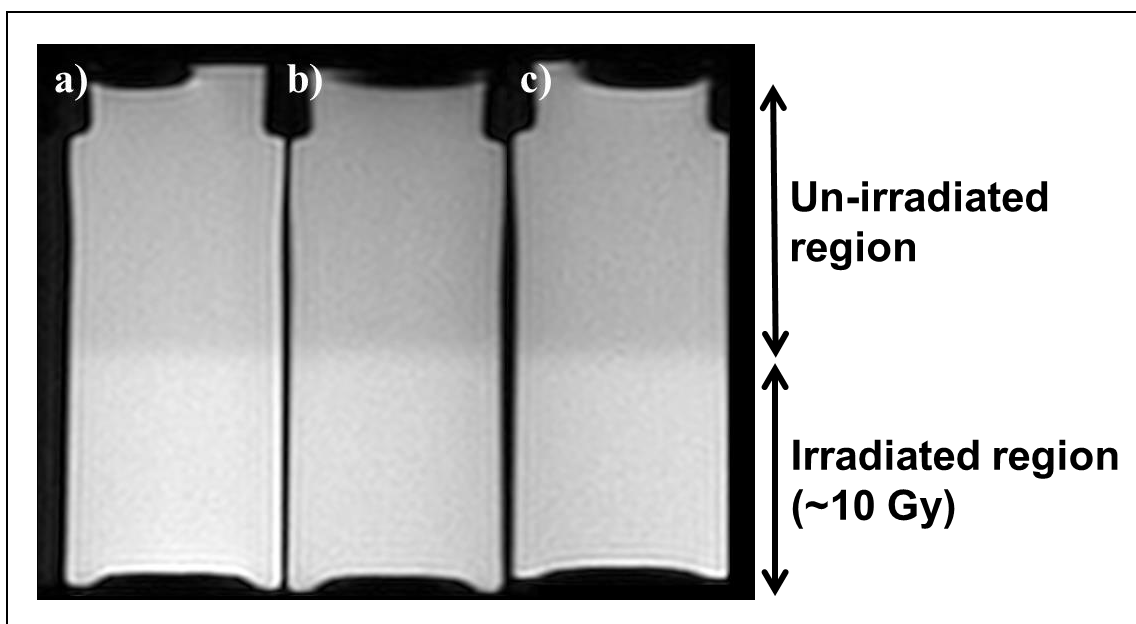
Gel matrix dependence. Post-irradiation T1-weighted images ($TR/TE = 500/20$ ms) of a) FOX in gelatin (4 wt %), b) FOX in gelatin (3 wt %) and agarose (1 wt %), and c) rFOX in gelatin (3 wt %) and agarose (1 wt %).
